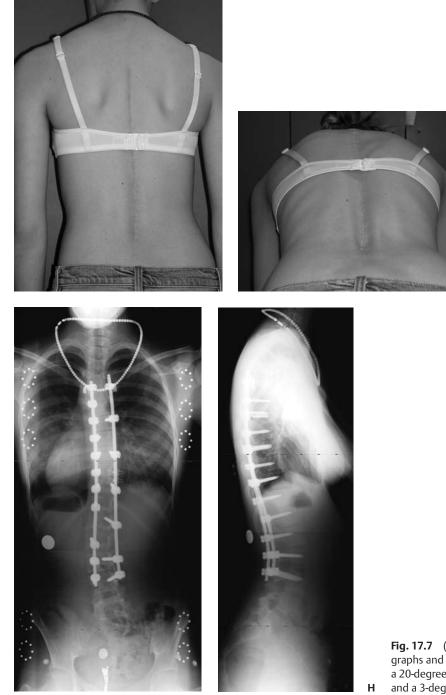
(*Continued*) (E,F) Postoperative clinical photographs and (G,H) PA and lateral radiographs demonstrate a 20-degree thoracic and 19-degree thoracolumbar curve, and a 3-degree clinical lumbar prominence.
